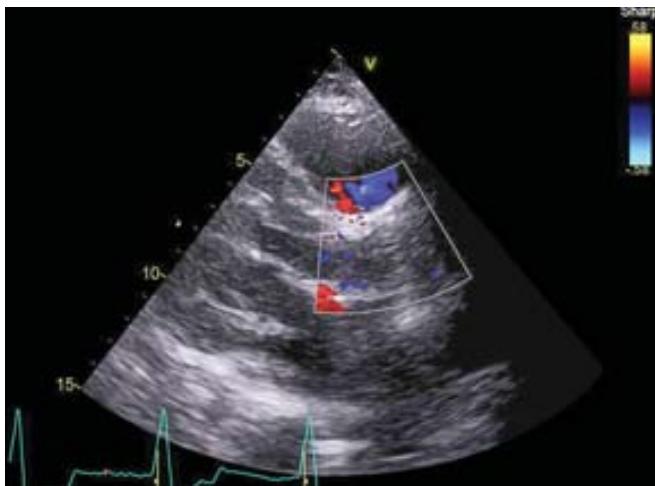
Transthoracic echocardiogram obtained postprocedure, showing valve *in situ* and no aortic regurgitation.
